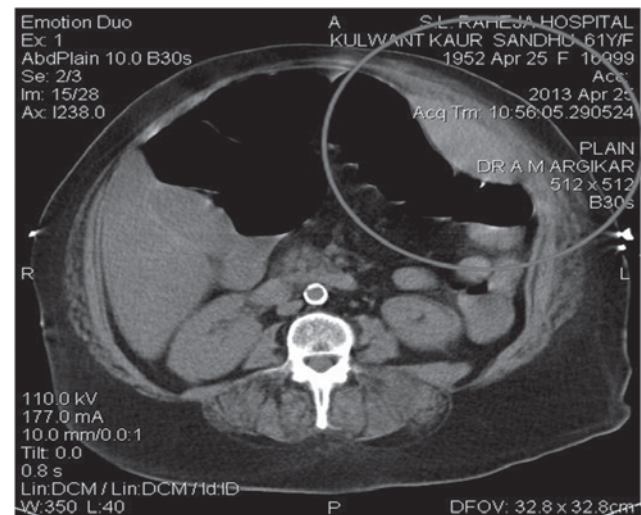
1 CT Abdomen showing rectus sheath hematoma in anterior abdominal wall (Encircling mark)
